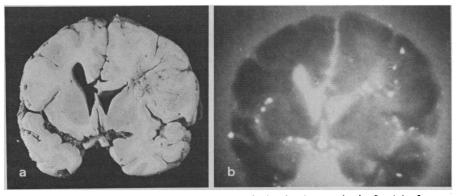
(a) Front view of a coronal slice 1 cm thick of a human brain fixed in formalin. Note the glioblastoma multiforme in the white matter of the hemisphere on the right, with swelling of the hemisphere and distortion of the ventricular system. (b) Proton radiograph. Note the decreased density in the tumor area and the visualization of the basal ganglia. The white spots are air bubbles. The conditions were 115-cm focus to film, no screen, Polaroid TLX film, and a dose to the first surface of approximately 290 rad in 0.8 minute.
